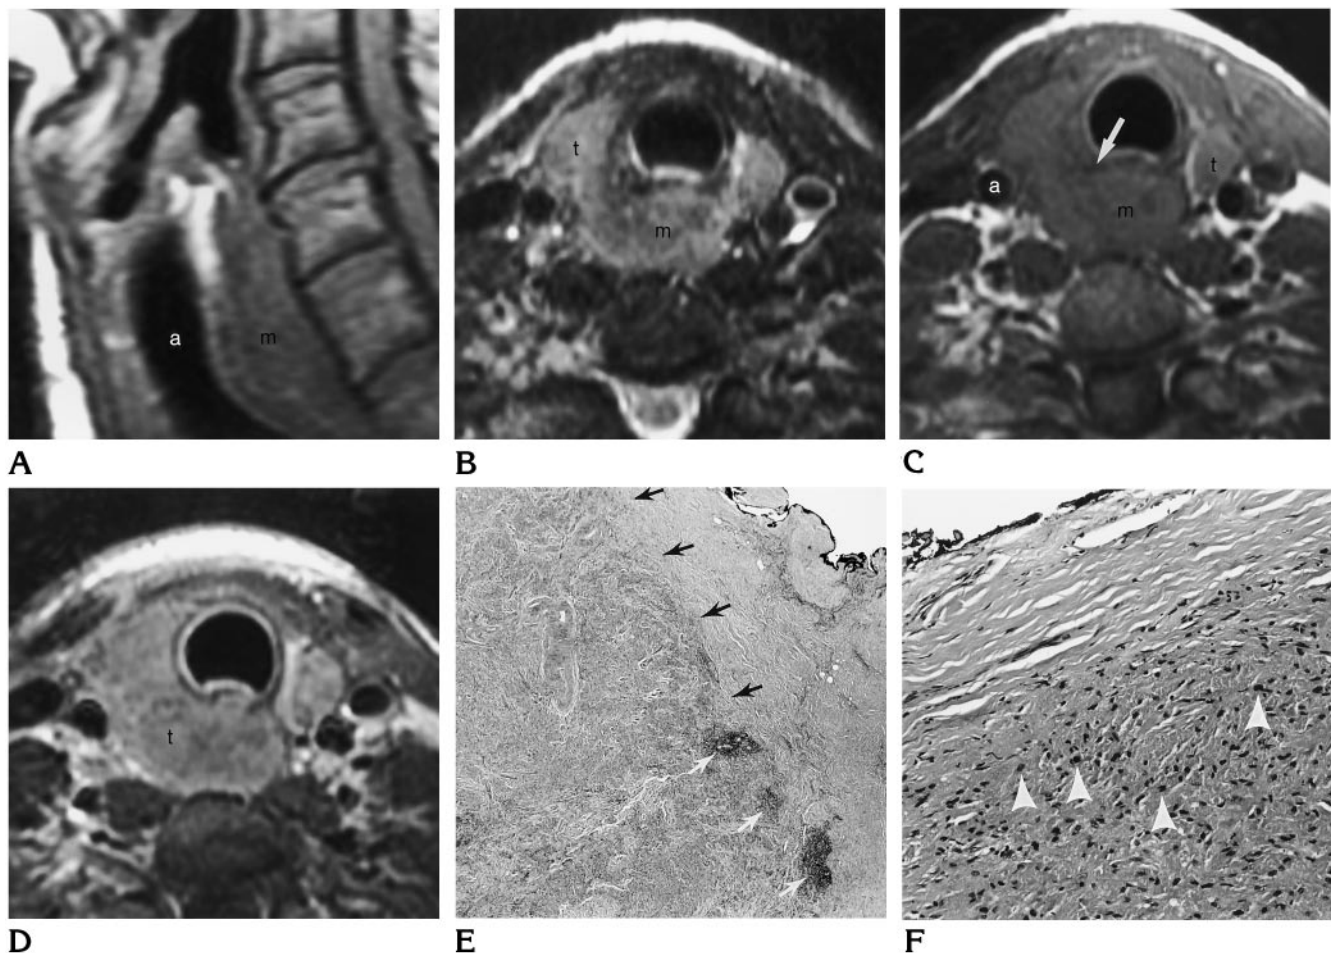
MR images in a 44-year-old man with a granular cell tumor of the cervical esophagus.
